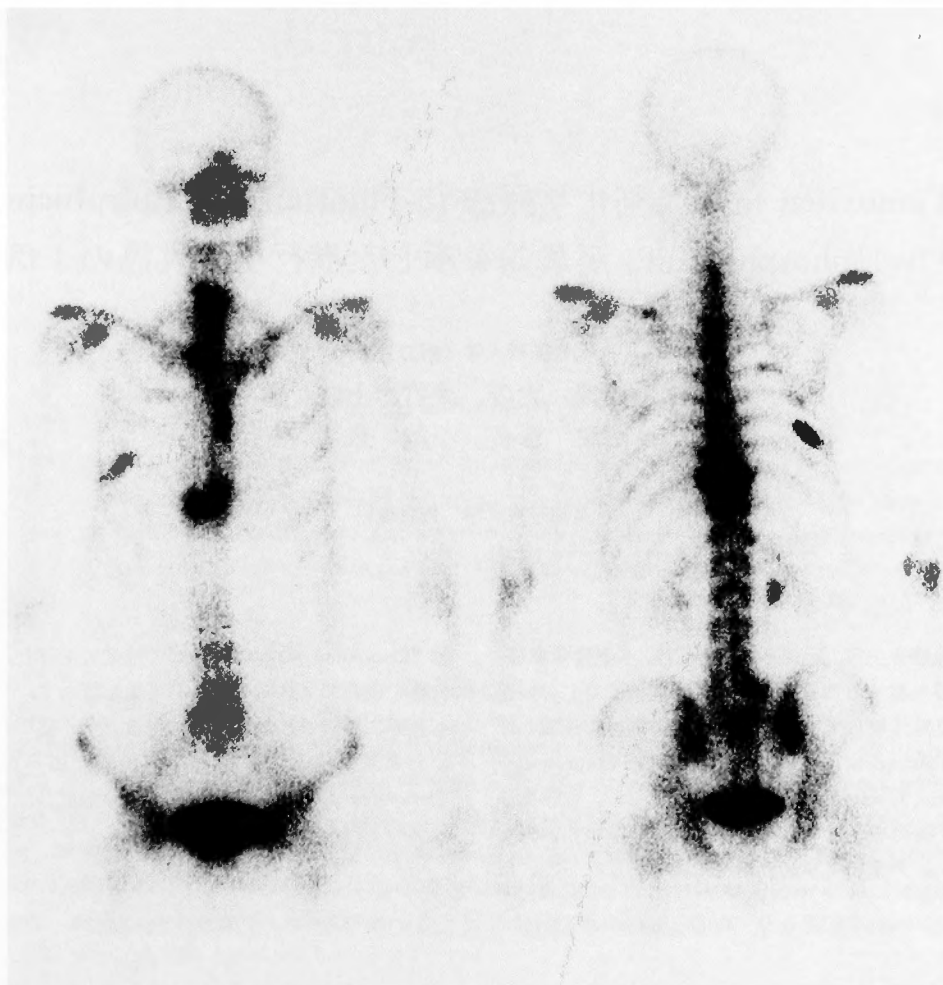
Bone scintigram in June 1994 demonstrated increased isotope uptake in the 10th thoracic vertebra and right 8th rib.
